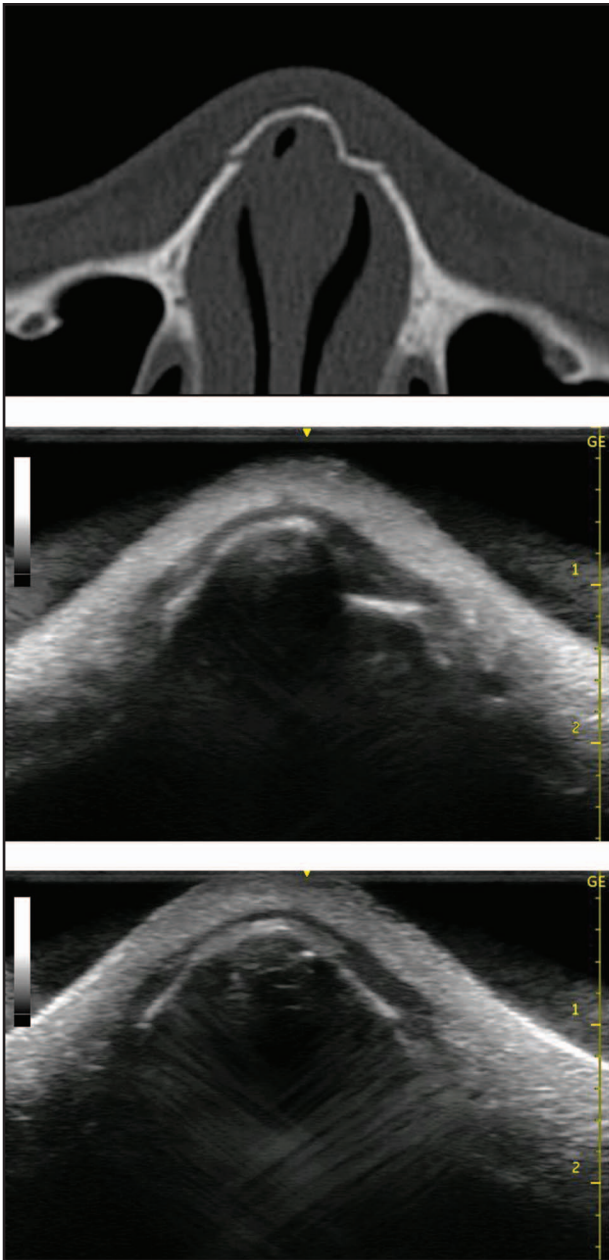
Case. A, A preoperative computed tomography scan image of a 16-year-old girl who had nasal bone fracture. B and C, Preoperative and postoperative ultrasound images with saline used as a coupling medium.
